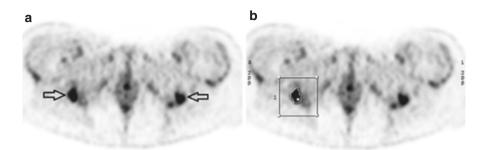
Transversal PET scan of the pelvis on the level of the ischial tuberosities. (a) Scan showed an increased FDG uptake in the area of the ischial tuberosities. (b) Measure of FDG uptake in the ROI (region of interest) of the left ischial tuberosity: SUV (standardized uptake value) maximum 8.2 and average 3.5
